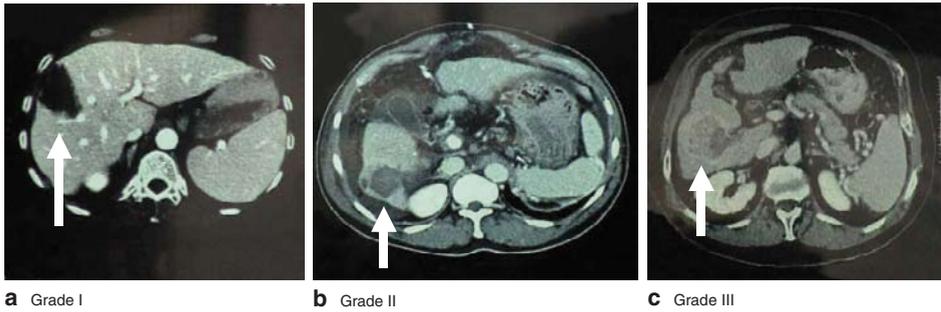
Typical computed tomograms of tumours according to Amin grade. a Grade I, 100 per cent avascularity; b grade II, more than 50 per cent avascularity; c grade III, less than 50 per cent avascularity (arrows show the induced coagulative necrosis)
